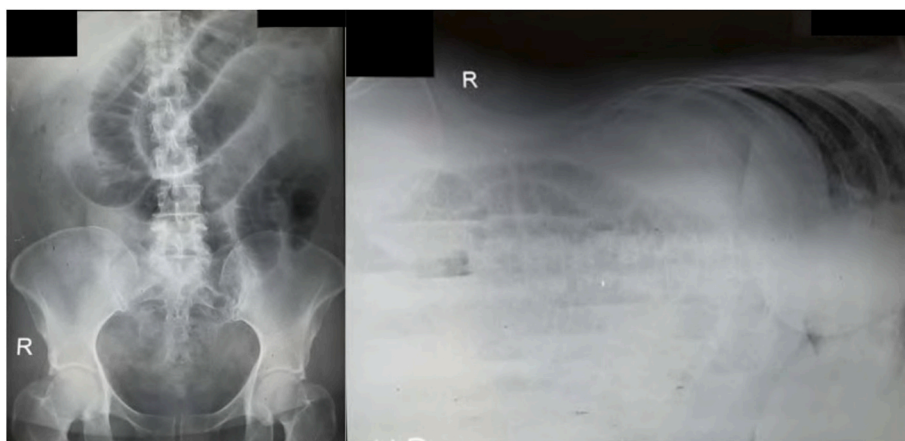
Abdominal plain x-ray supine and left lateral decubitus showed fixed central small bowel distention with air-fluid level.
